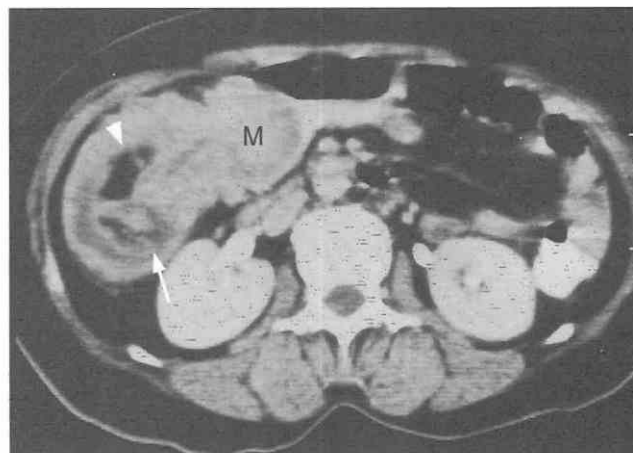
Intercolic intussusception due to inflammatory fibroid tumor of the ileum. CT scan shows a heterogeneous mass in the right-sided colon with interposed mesenteric fat (arrowheads) and vessels (arrows). A round mass (M) is seen at the lead point.
